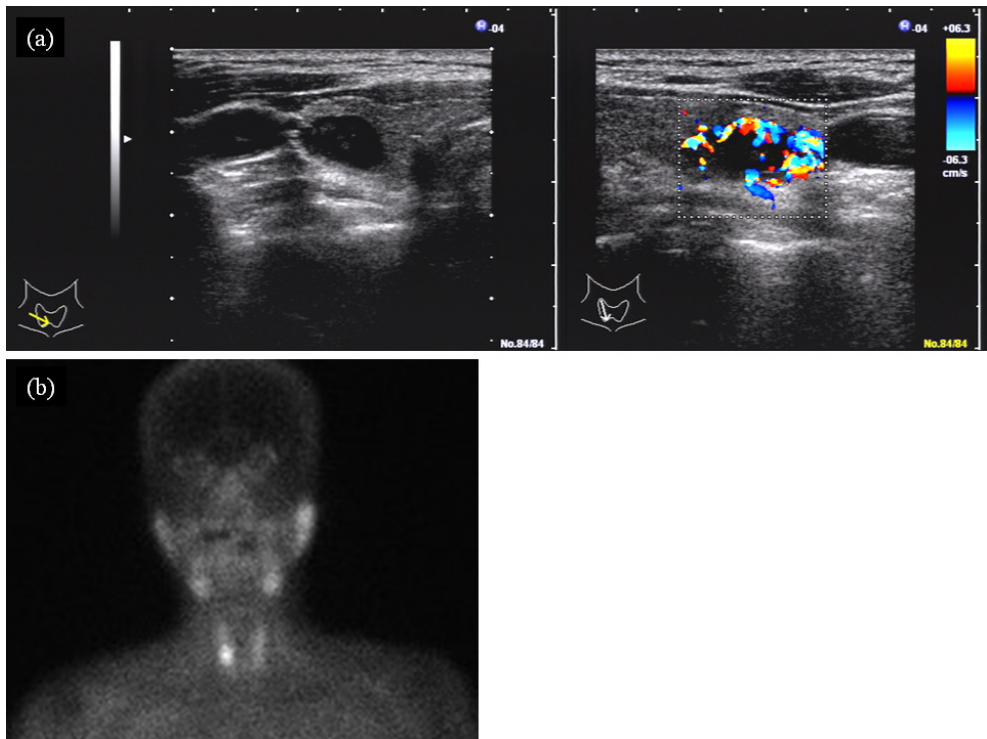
a) Ultrasonography of the right lobe of the thyroid showing a hypoechoic and hypervascular Doppler signaling mass impacted within the thyroid.
